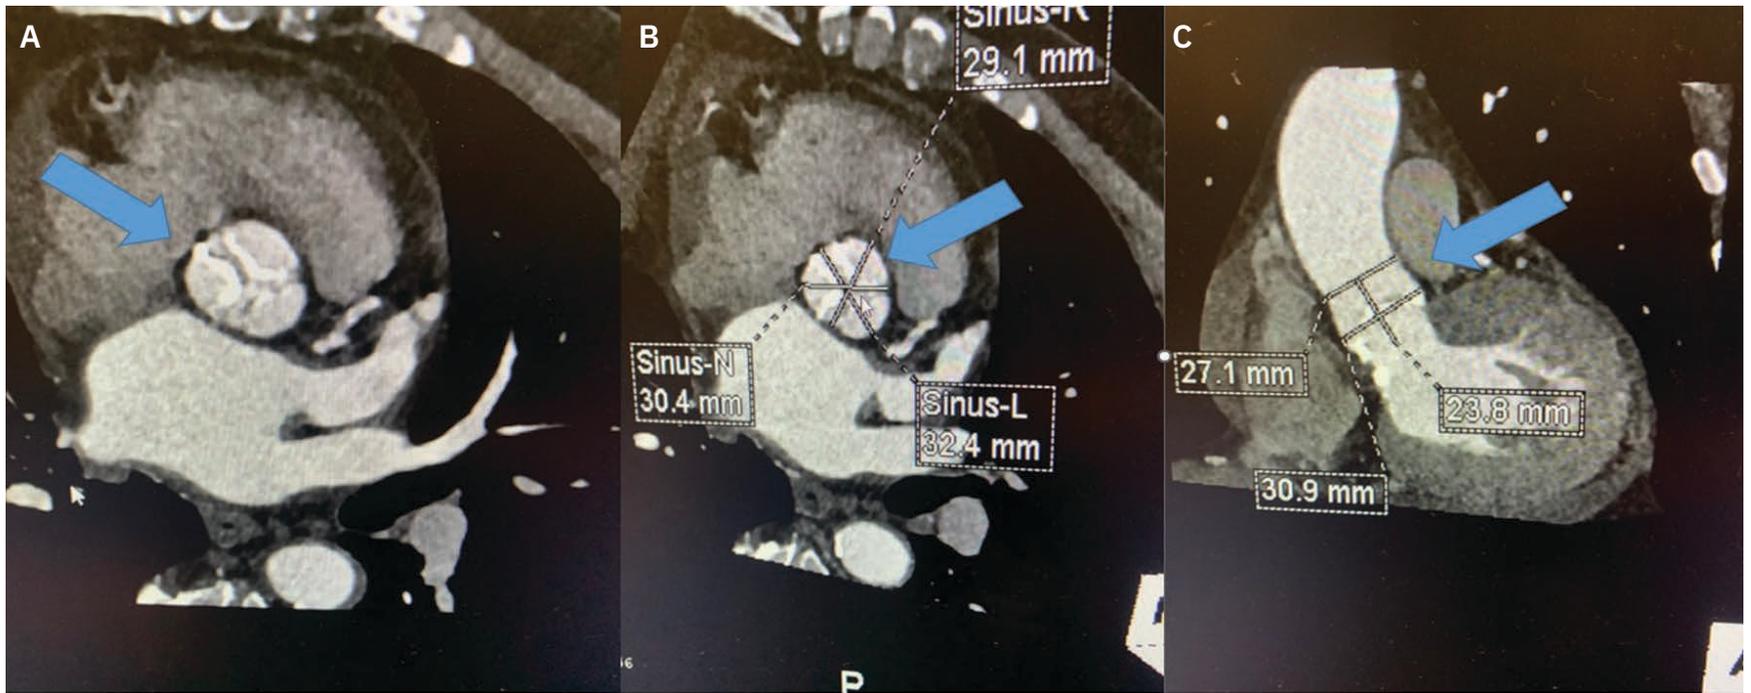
CT measurements taken as part of a pre-TAVR workup to assess the aortic valve.
